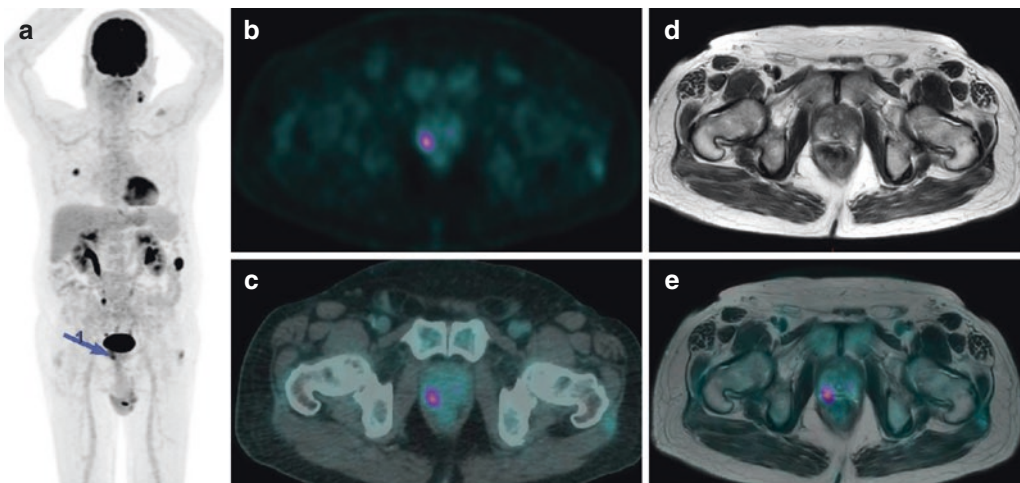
The patient was examined for restaging colon cancer. Beyond abdominal and lung metastases of colon cancer (Maximum PET Intensity Projection, a), incidentally, an area of focal ^{18}F -FDG uptake was detected in the right prostate lobe, as evident in MIP (a, arrow) and axial
